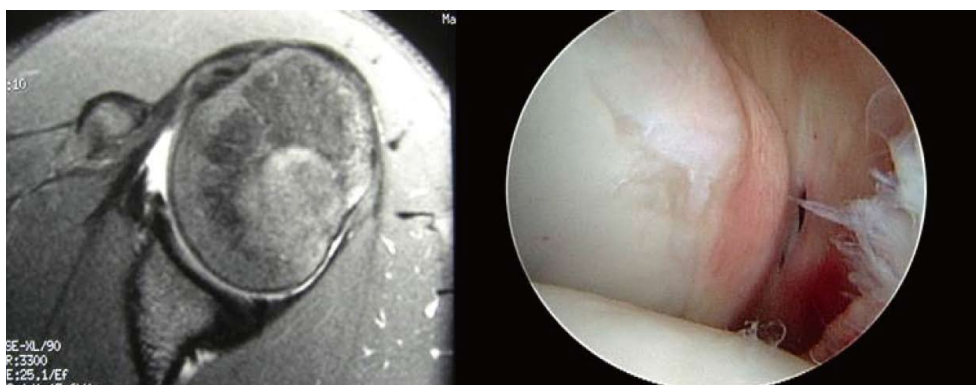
Magnetic resonance image of Bennett lesion and corresponding arthroscopic picture viewing posteriorly from anterosuperior portal.
